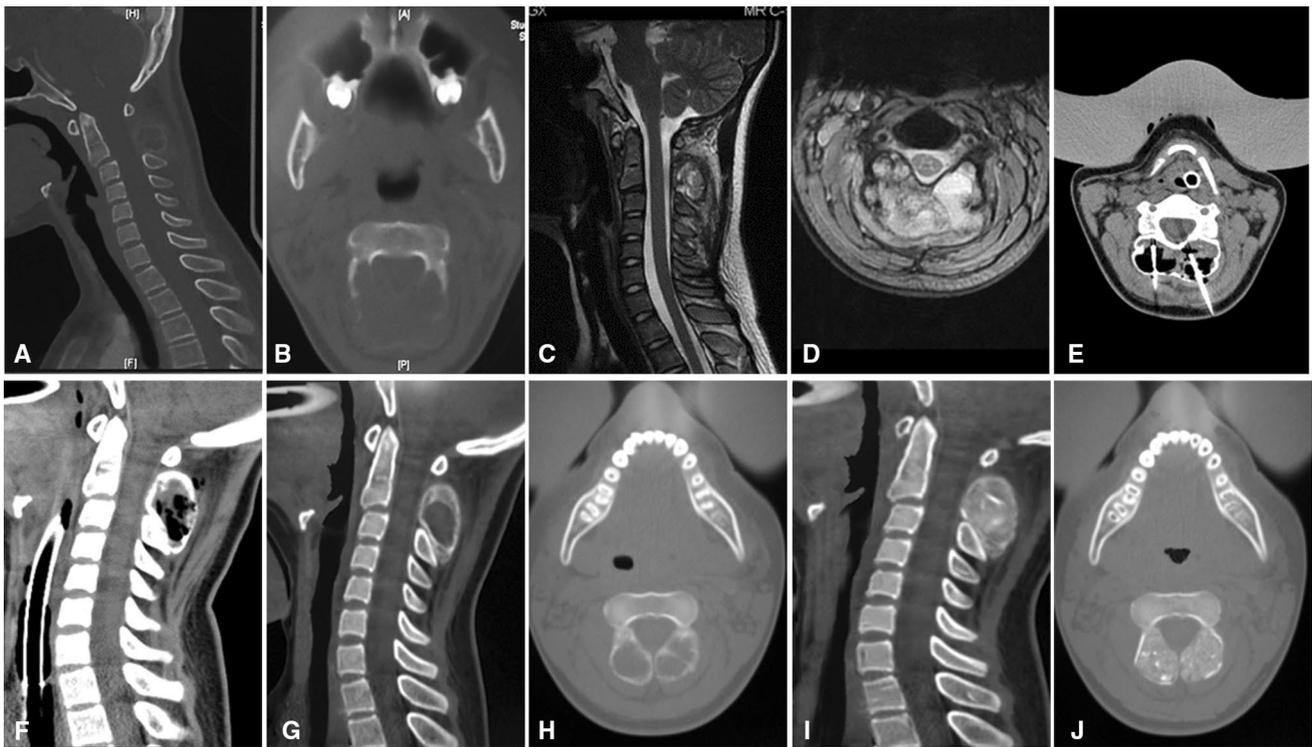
Representative case of a 18-year-old female experiencing neck pain for 4 months. a and b CT scans showed an expansive osteolytic lesion of the C2 neural arch. c and d MRI scans further revealed multiple septa and fluid–fluid levels within the lesion. e and f It is easier to manipulate when the lesion is located in the neural arch. During
